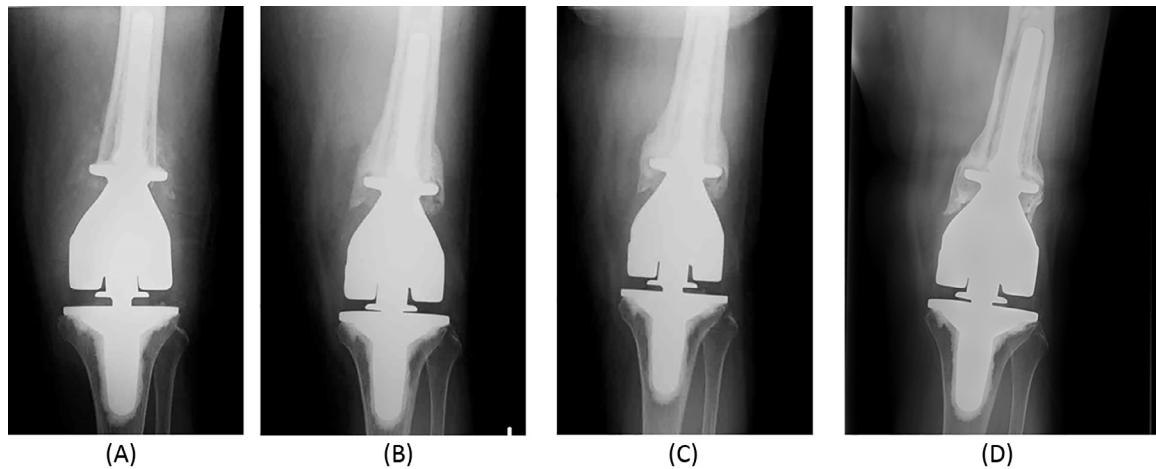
Frontal radiographs of the knee at (A) 2 weeks, (B) 6 months, (C) 1 year, and (D) 7 years postoperatively.
